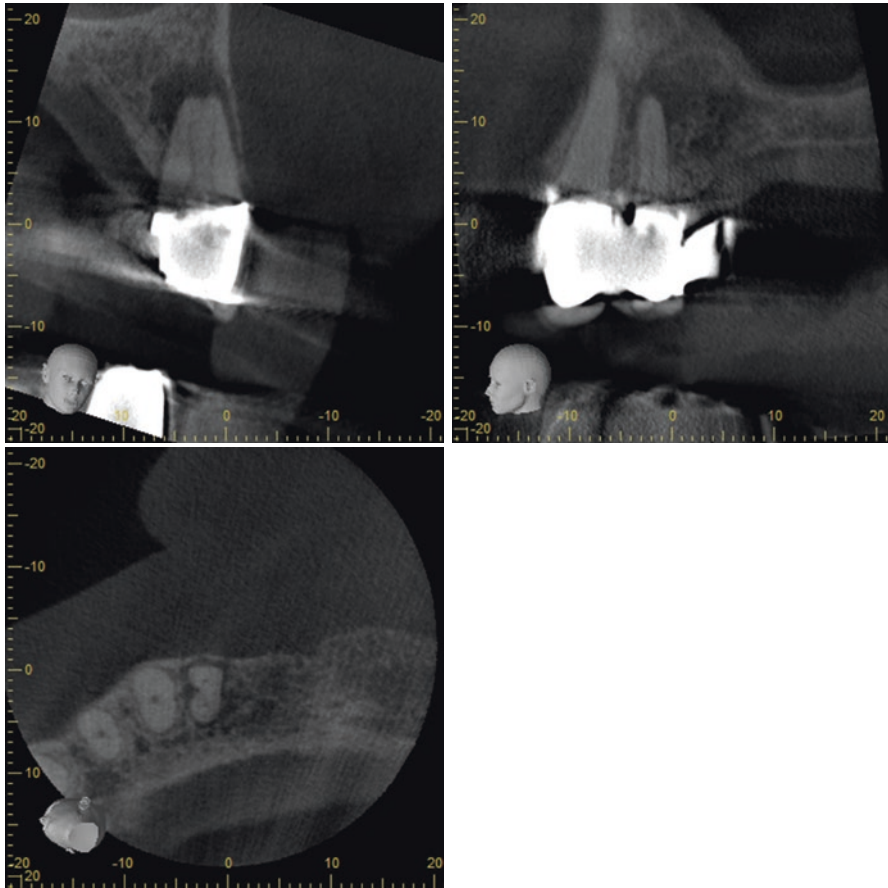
CBCT-Slices showing no procedural problems, the obliteration, the extent of the AP and the canal configuration as the location of the orifices
